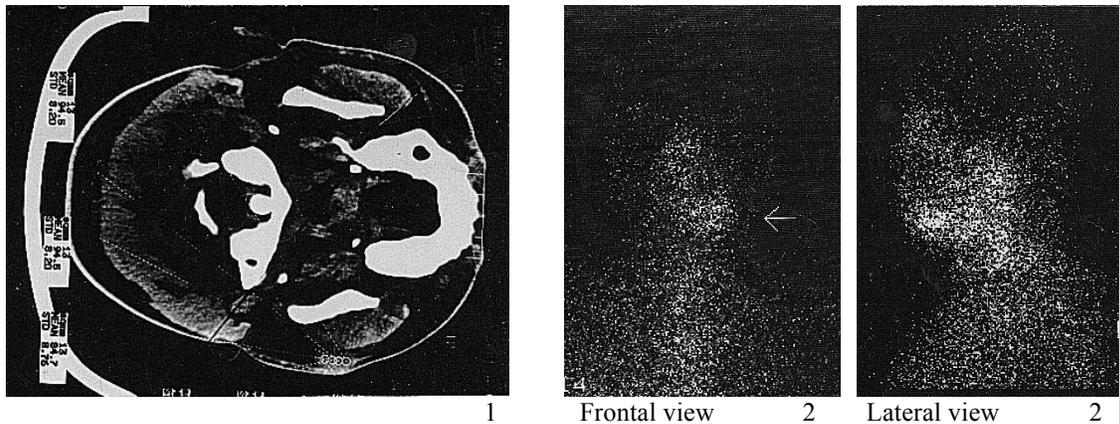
CT showed left parotid gland benign tumor, and were diagnosed as malignant pleomorphic adenoma by pathological examination.
